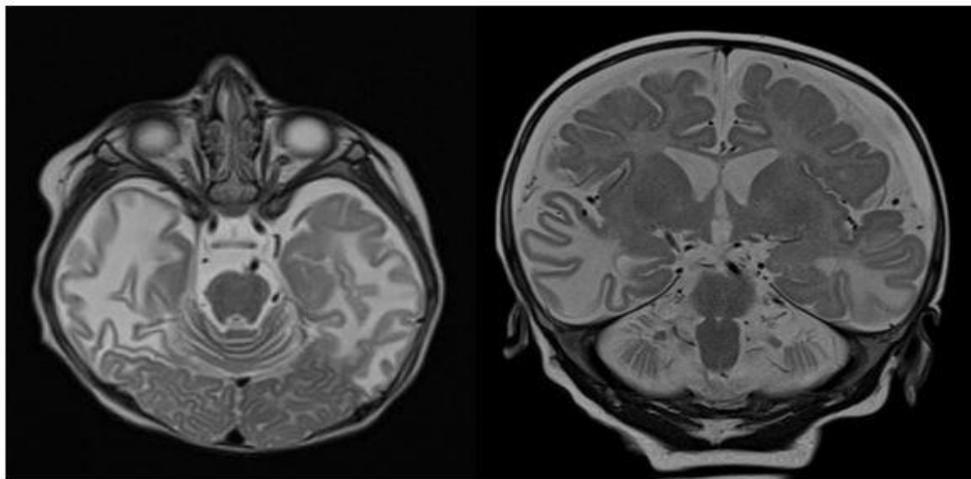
Diffuse subcortical white matter signal changes in the bilateral temporo- parietal regions suggestive of gliosis with hypo intense signal in T1 and FLAIR images with hyper- intense signal in T2 with no restricted diffusion or blooming artifacts.
